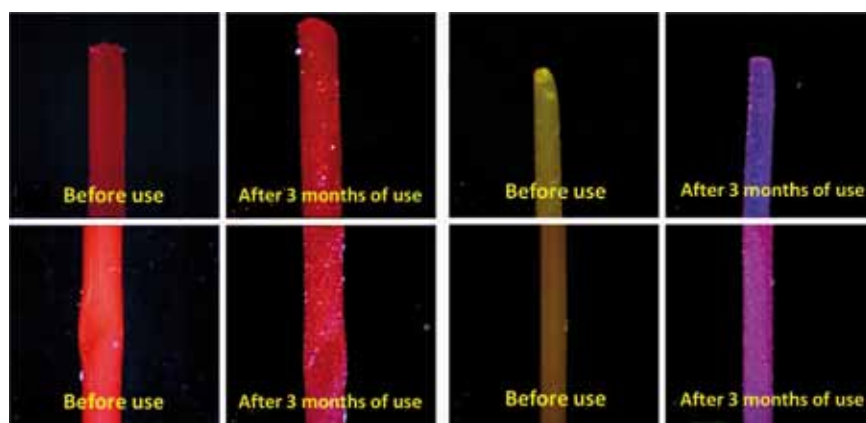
External change in textured Tynex nylon bristles, R.O.C.S. Black Edition (1) and polyester bristles CURAPROX 5460 Ultrasoft (2) through various stages of their use. Magnification $\times 4$.
